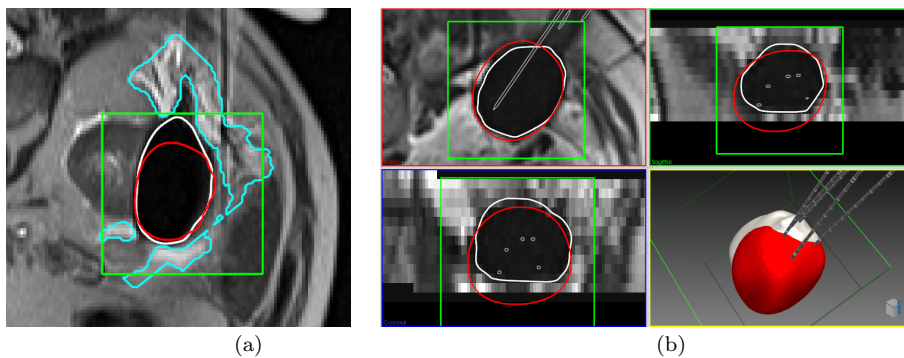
(a) detail of an intraoperative axial MRI showing the “comet tail” effect in patient case 1. Superimposed are the cube (green), the ground-truth iceball contour (white), the computed iceball contour (red), and the saline solution (light blue); (b) detail of patient case 5 showing the two lower probes that were set to 60% of their freezing power. Both cases were computed within a 60mm cube.
